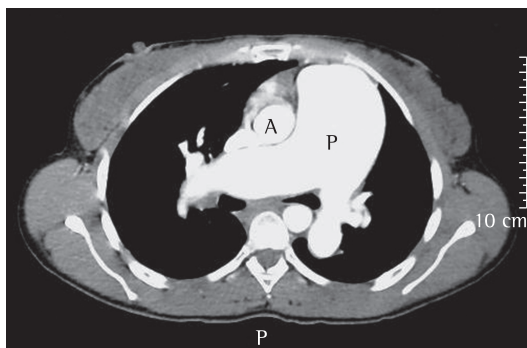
CT angiography revealing dilatation of the pulmonary artery trunk and its branches. A: aorta; P: pulmonary artery trunk.
